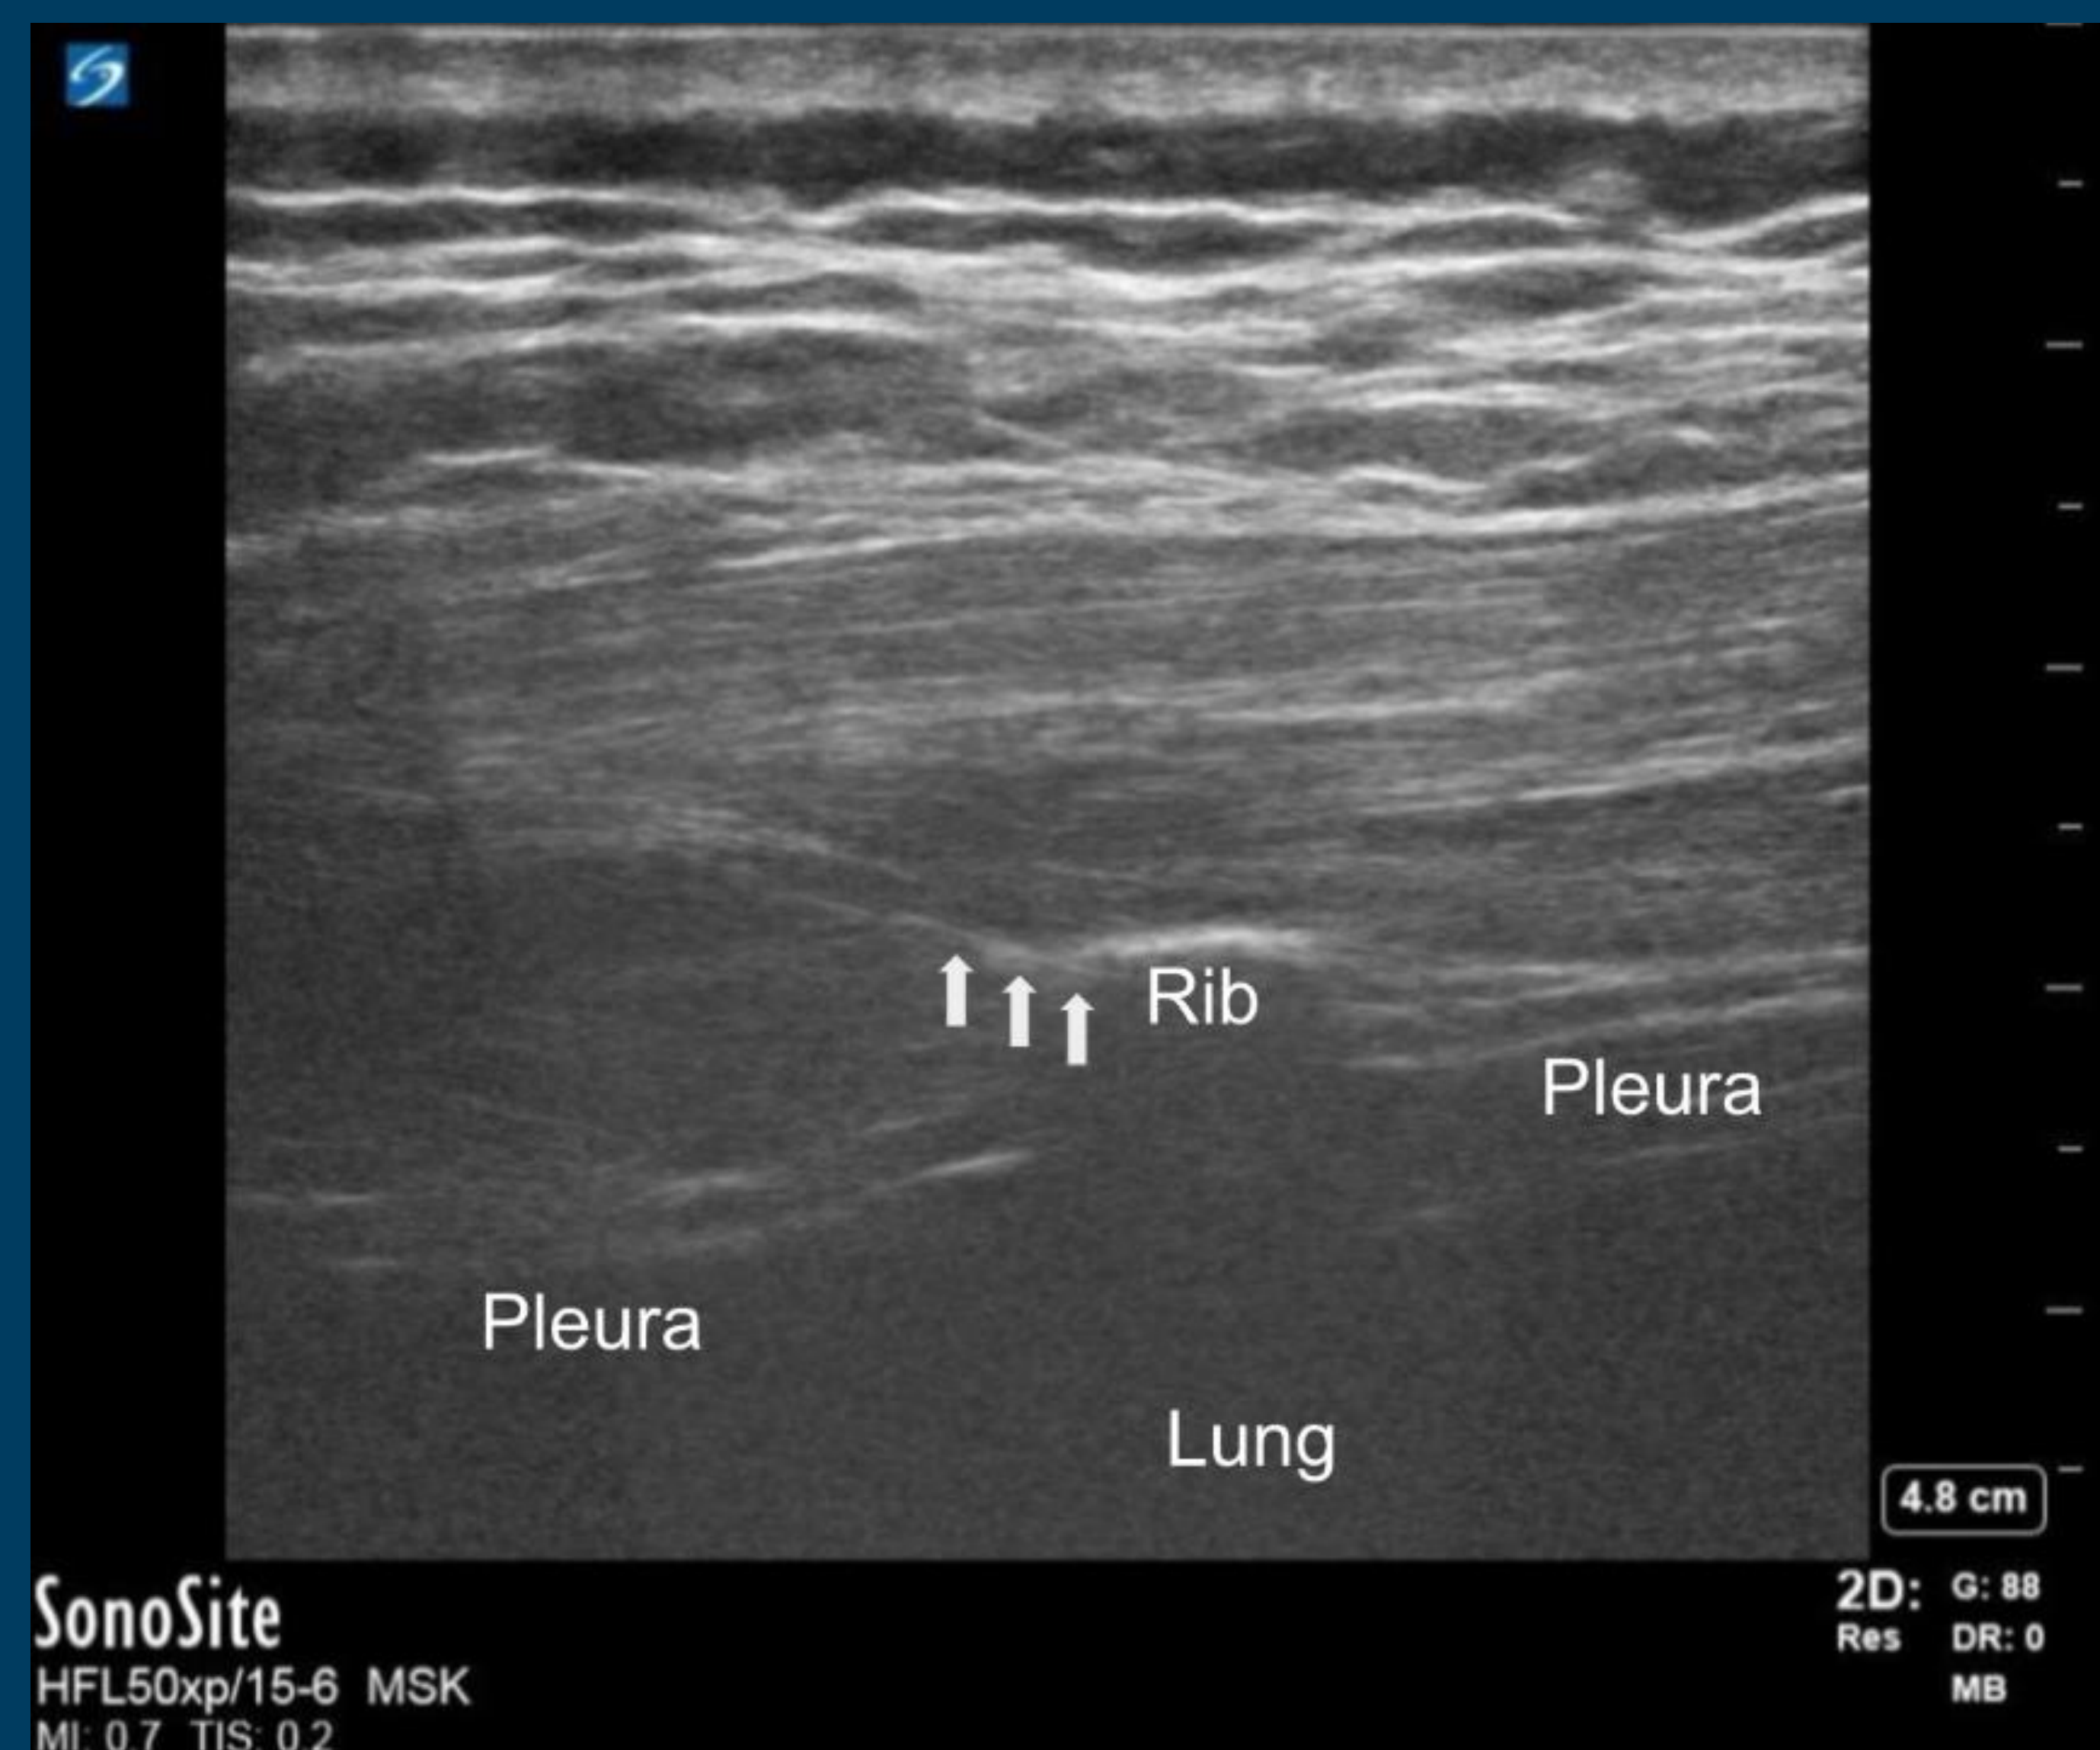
Ultrasound image of the proximal intercostal nerve block. The needle (arrows) is seen piercing the external intercostal muscle with the tip just deep to the internal intercostal membrane at the caudal border of the tenth rib.
